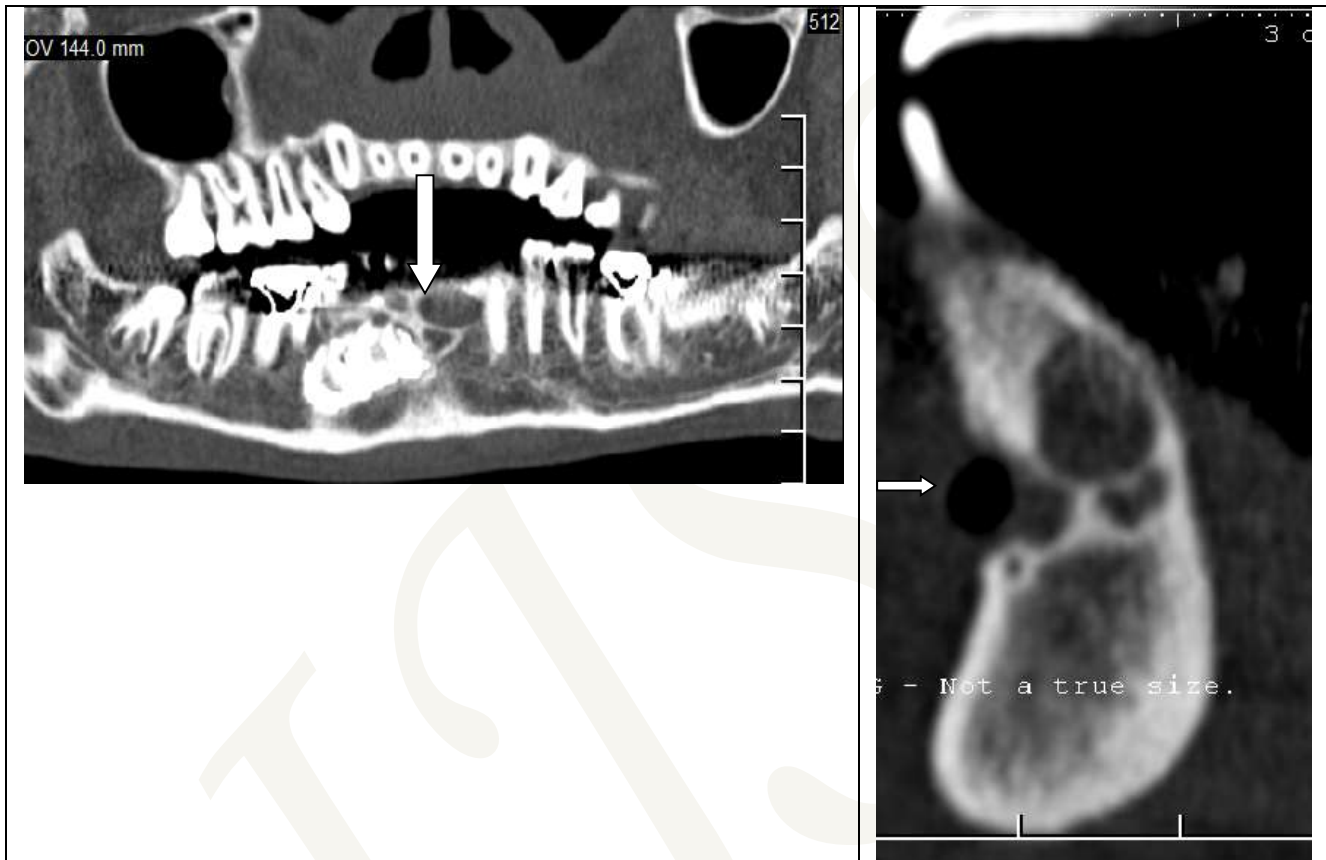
A case of ameloblastoma. 1a. Panoramic view Dental CT showing extent of lesion. Note that the artifacts from the Dental caps are seen to project over the crowns of teeth and away from the lesion (arrow)
